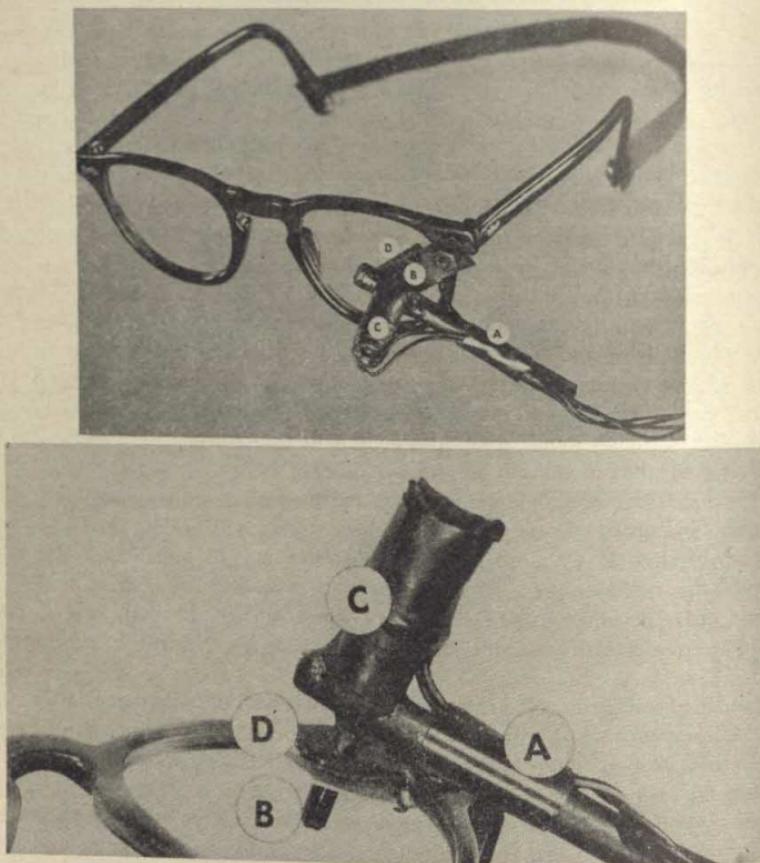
SPECTACLE FRAMES WITH CONDITIONING UNIT MOUNTED ON RIM
